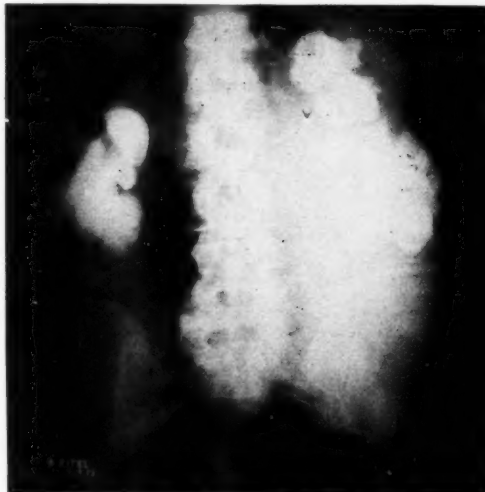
X-ray showing large calculi with shadows in the course of the ureter on the left and a cluster of shadows overlying the lower pole of the right kidney.
